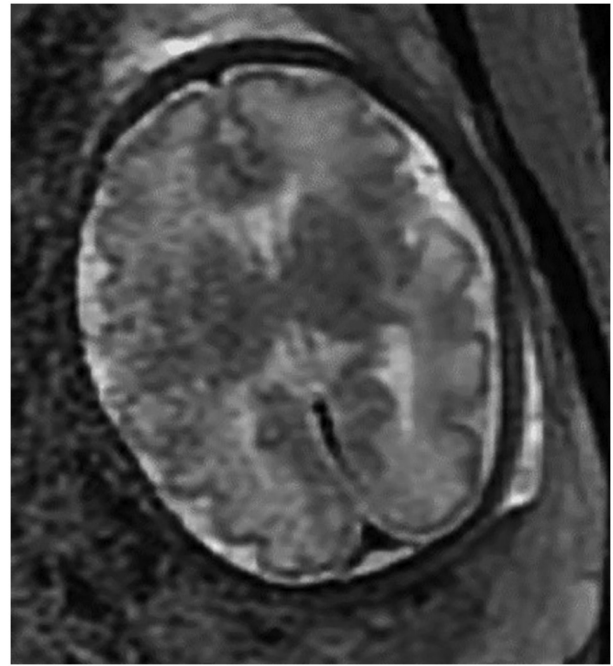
Fetal magnetic resonance imaging at 32 weeks, axial view of the fetal brain (TSE, T2), normal gyration and brain parenchyma.
